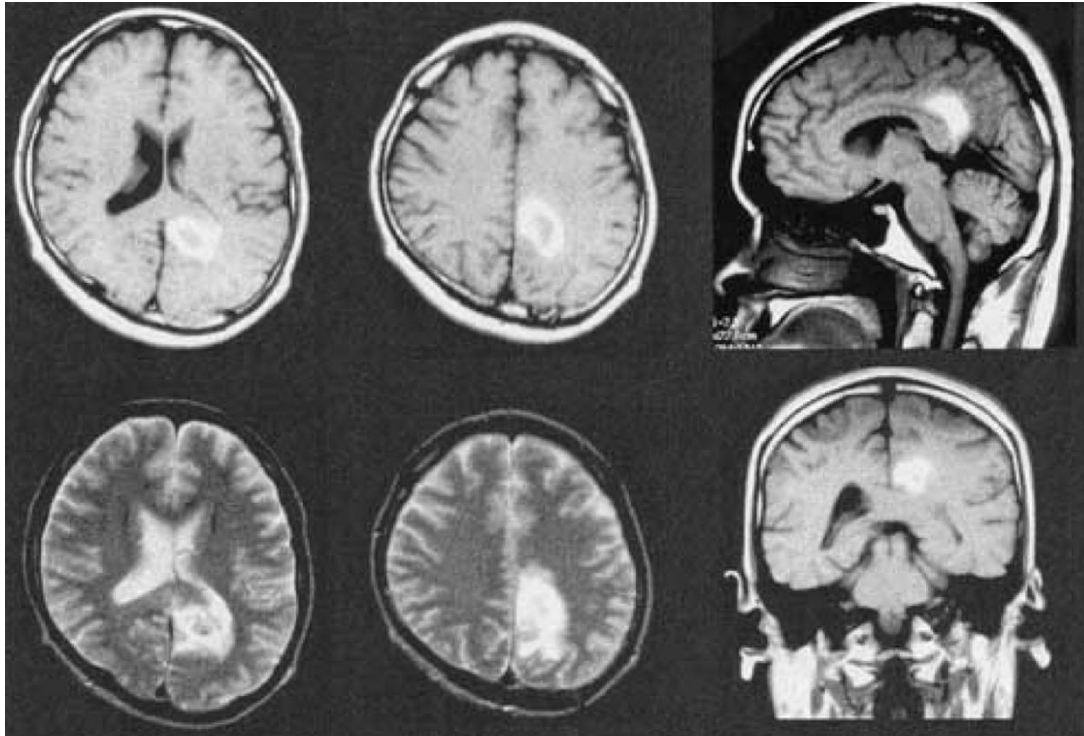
Example of a human RSC lesion. MRI of a subcortical haematoma (axial, sagittal and coronal views) in a patient with spatial disorientation. The lesion includes RSC, but as with many lesions involving this region, there is also extensive pathology to more lateral, superior and posterior areas. (From Maeshima et al., 2001, with permission from Elsevier).
